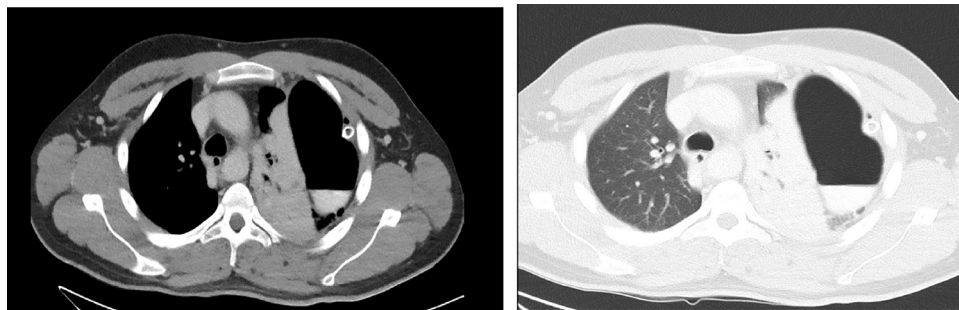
Axial images of the CT chest post insertion of left intercostal catheter.
